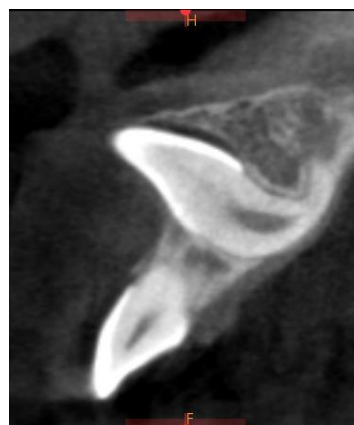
CBCT images of dilacerated impacted maxillary left central incisor.
